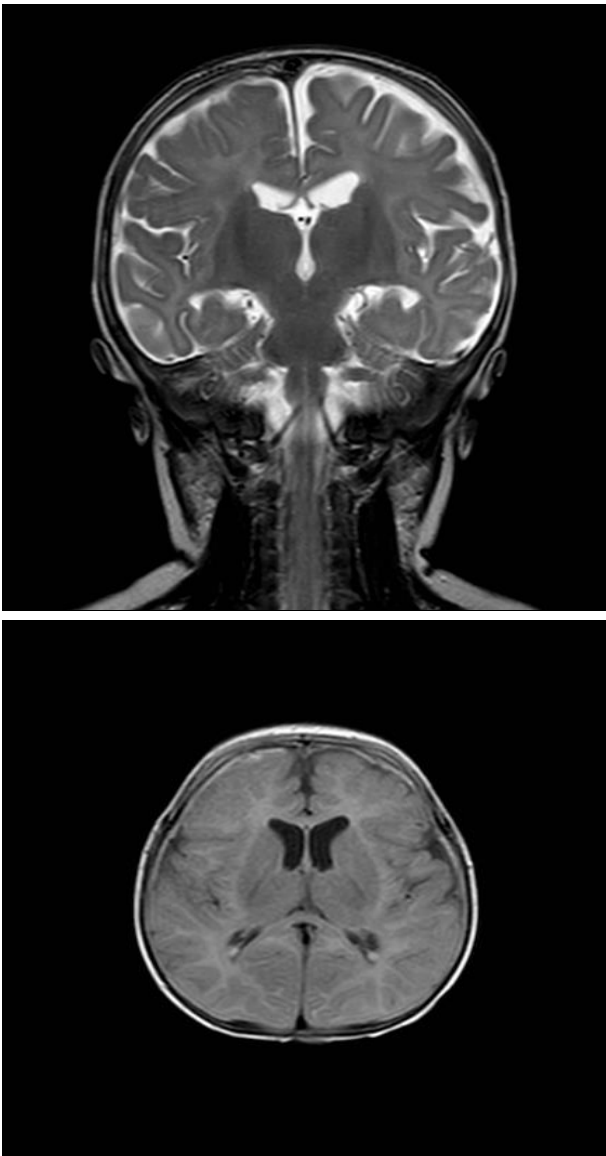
4A y 4B: MRI three months after surgical evacuation and subdural Gentamicin administration, showing complete empyemas resolution with adequate brain re-expansion
